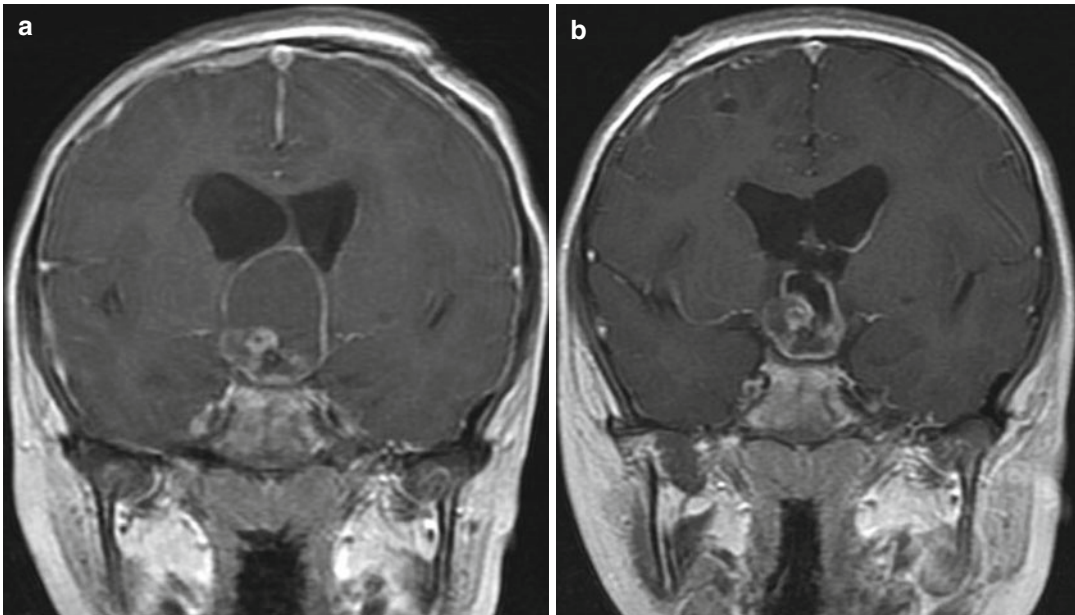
Contrast-enhanced MRI from a patient with a recurrent cystic craniopharyngioma who presented with visual deterioration. The preoperative image (a) demonstrates the large dimension and mass effect from the tumor
